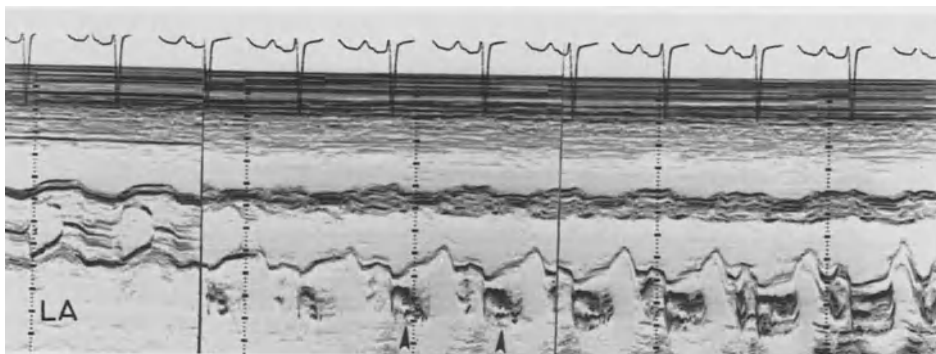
M-Mode echocardiogram showing vegetation on mitral valve (arrow) prolapsing into left atrium (LA).
